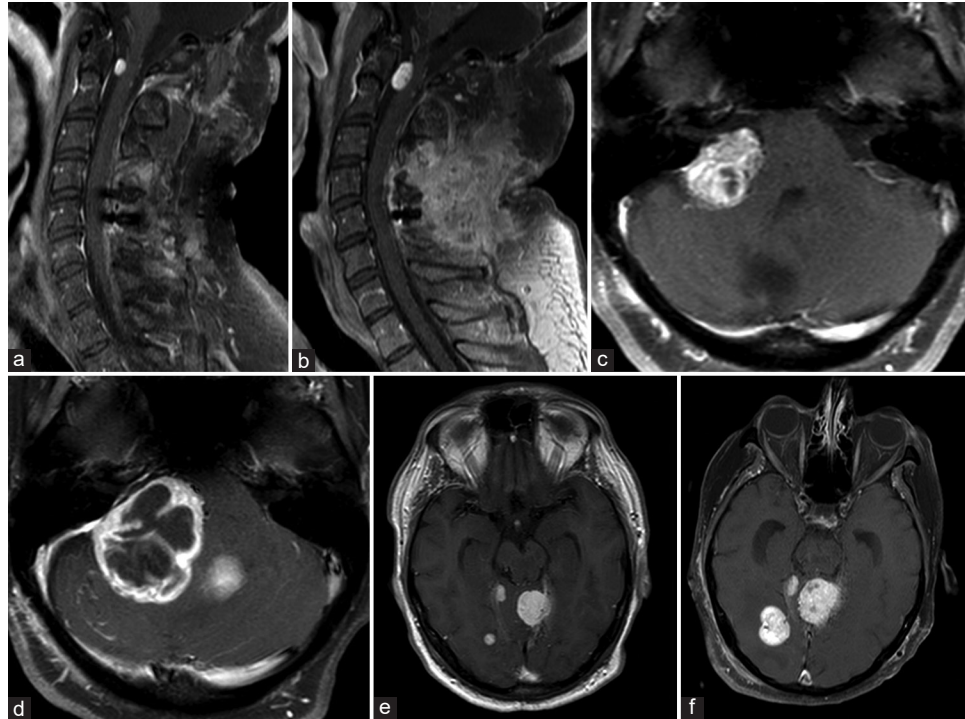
Images demonstrating the aggressive progression of the lesions. Gadolinium-enhanced T1-weighted sagittal cervical spine MRI showing a ventral intradural extramedullary lesion at C1 in October 2019 (a); MRI performed in December 2019 demonstrated rapid progression of the lesion and spinal cord compression (b). MRI showing a right cerebellopontine angle tumor in December 2019 (c); expansion of the lesion was observed in April 2020, causing brainstem compression and fourth ventricle displacement (d). MRI showing a small right temporo-occipital tumor and a left tentorial tumor in January 2020 (e); growth of both lesions was observed in July 2020 (f).
